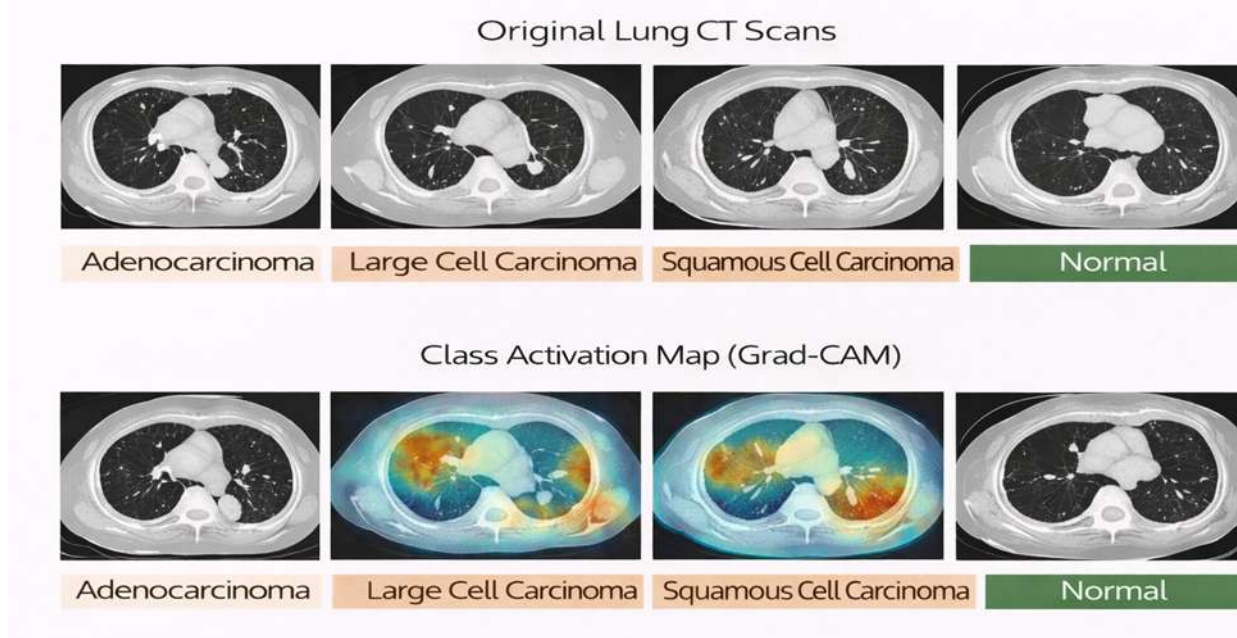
CT Scan Sample Images
